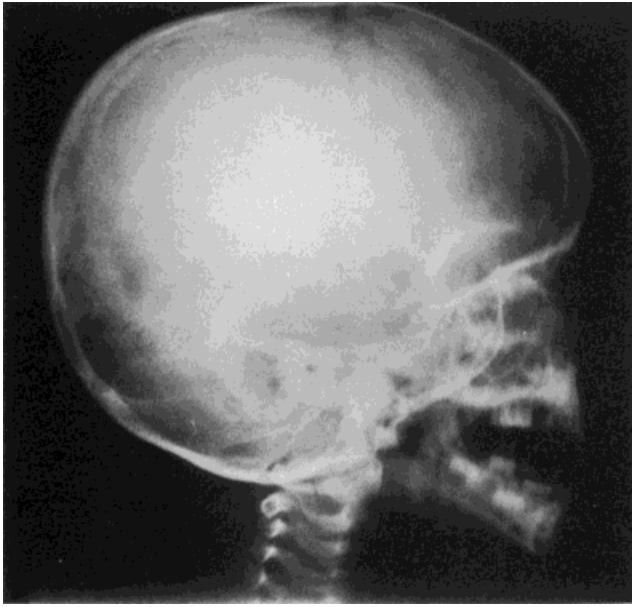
Patient C, X-ray photograph at 4 years. Note disproportionate cranium, enlarged posterior fossa, and verticalized base of cranium.
